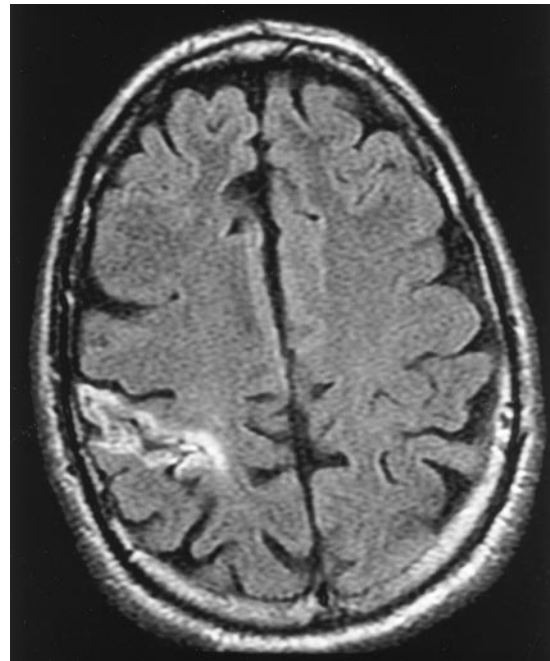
MRI FLAIR sequences revealed increased signal intensity isolated to the postcentral gyrus. The infarction was limited to the gray matter and was extended approximately 2 cm above and below this representative slice.
